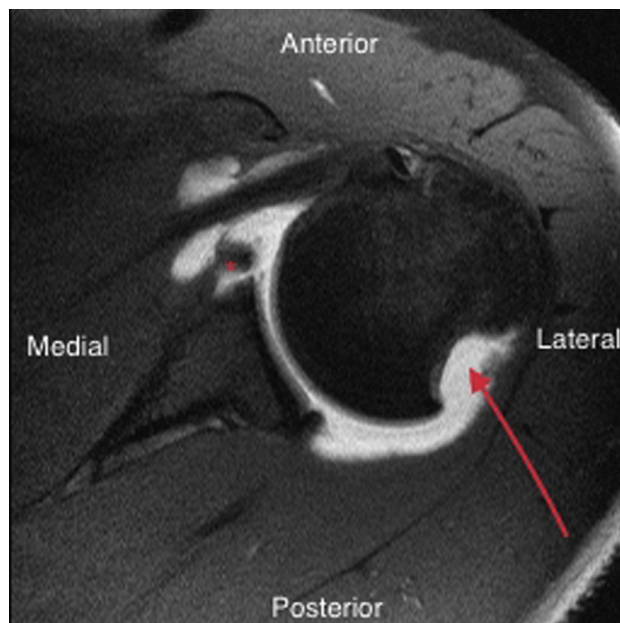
Pre-Latarjet preoperative axillary magnetic resonance image showing large Bankart lesion and Hill-Sachs lesion. *Star* shows bony Bankart lesion; *arrow* indicates the Hill-Sachs lesion.
